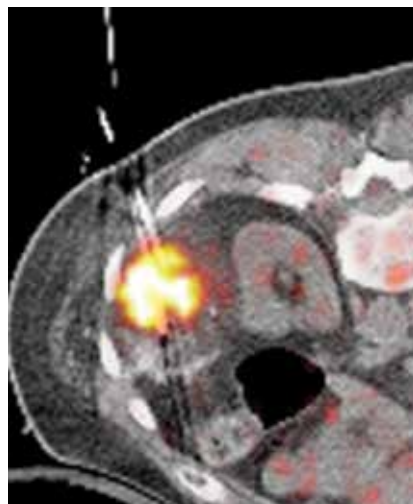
Fused PET/CT performed towards the end of the cryoablation at the level of lower cryoablation probes shows persistent tracer uptake within the tumor and a hypodense ice ball on CT extending beyond the  $^{18}\text{F}$ -FDG avid tumor. This confirms an adequate ablation margin including and extending beyond the entire tumor. Note the bowel wall is at a significant distance from the cryoablation zone, which has been achieved by hydro-displacement.
